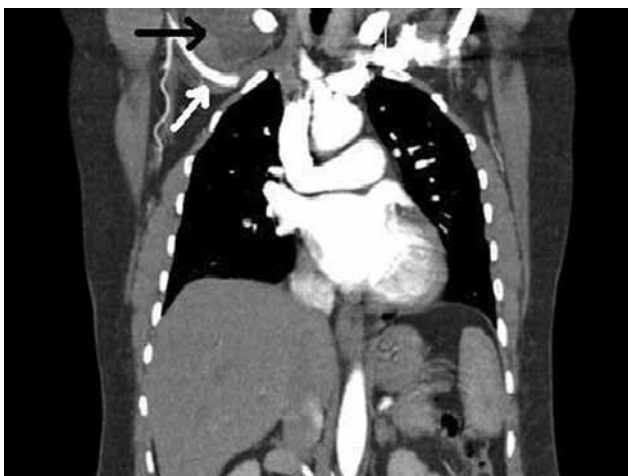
Computed tomography shows a mass measuring 74x73x55 mm in diameter in the right thoracic outlet (black arrow). The subclavian artery was in the inferior position (white arrow).
